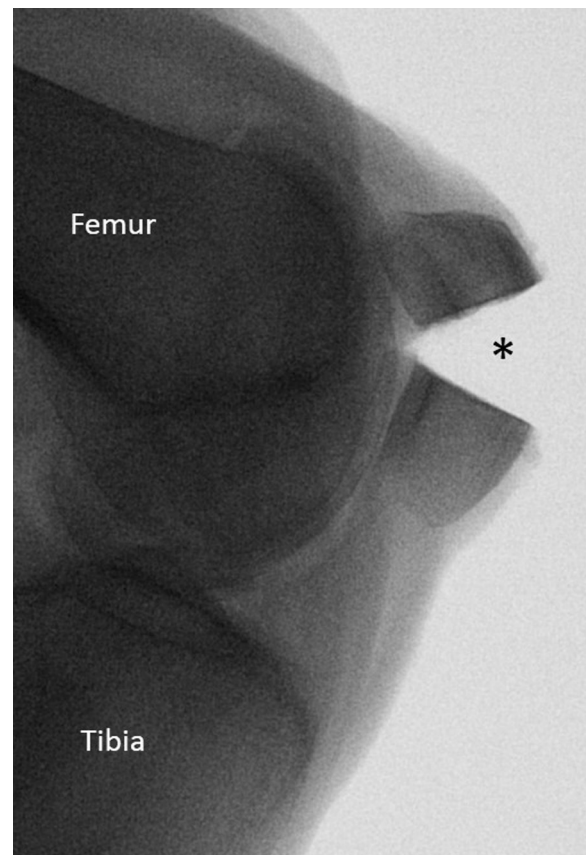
Left knee: preoperative lateral radiograph demonstrating a simple transverse fracture through the middle third of the patella (*).
